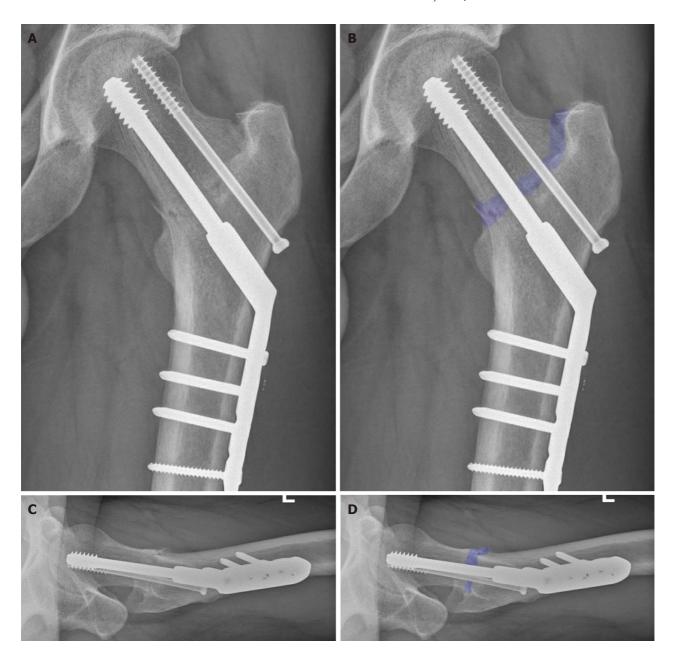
Position of osteosynthesis material at outpatient clinic follow-up. A: Coronal X-ray without overlay; B: Coronal X-ray including an overlay, highlighting the fracture; C: Lateral X-ray without overlay; D: Lateral X-ray including an overlay, highlighting the fracture. During the outpatient clinic follow-up, the patient was almost free of complaints and the alignment was consistent with before. At this time, there were no convincing signs of bone remodeling, which is also not expected with this atypical fracture.
